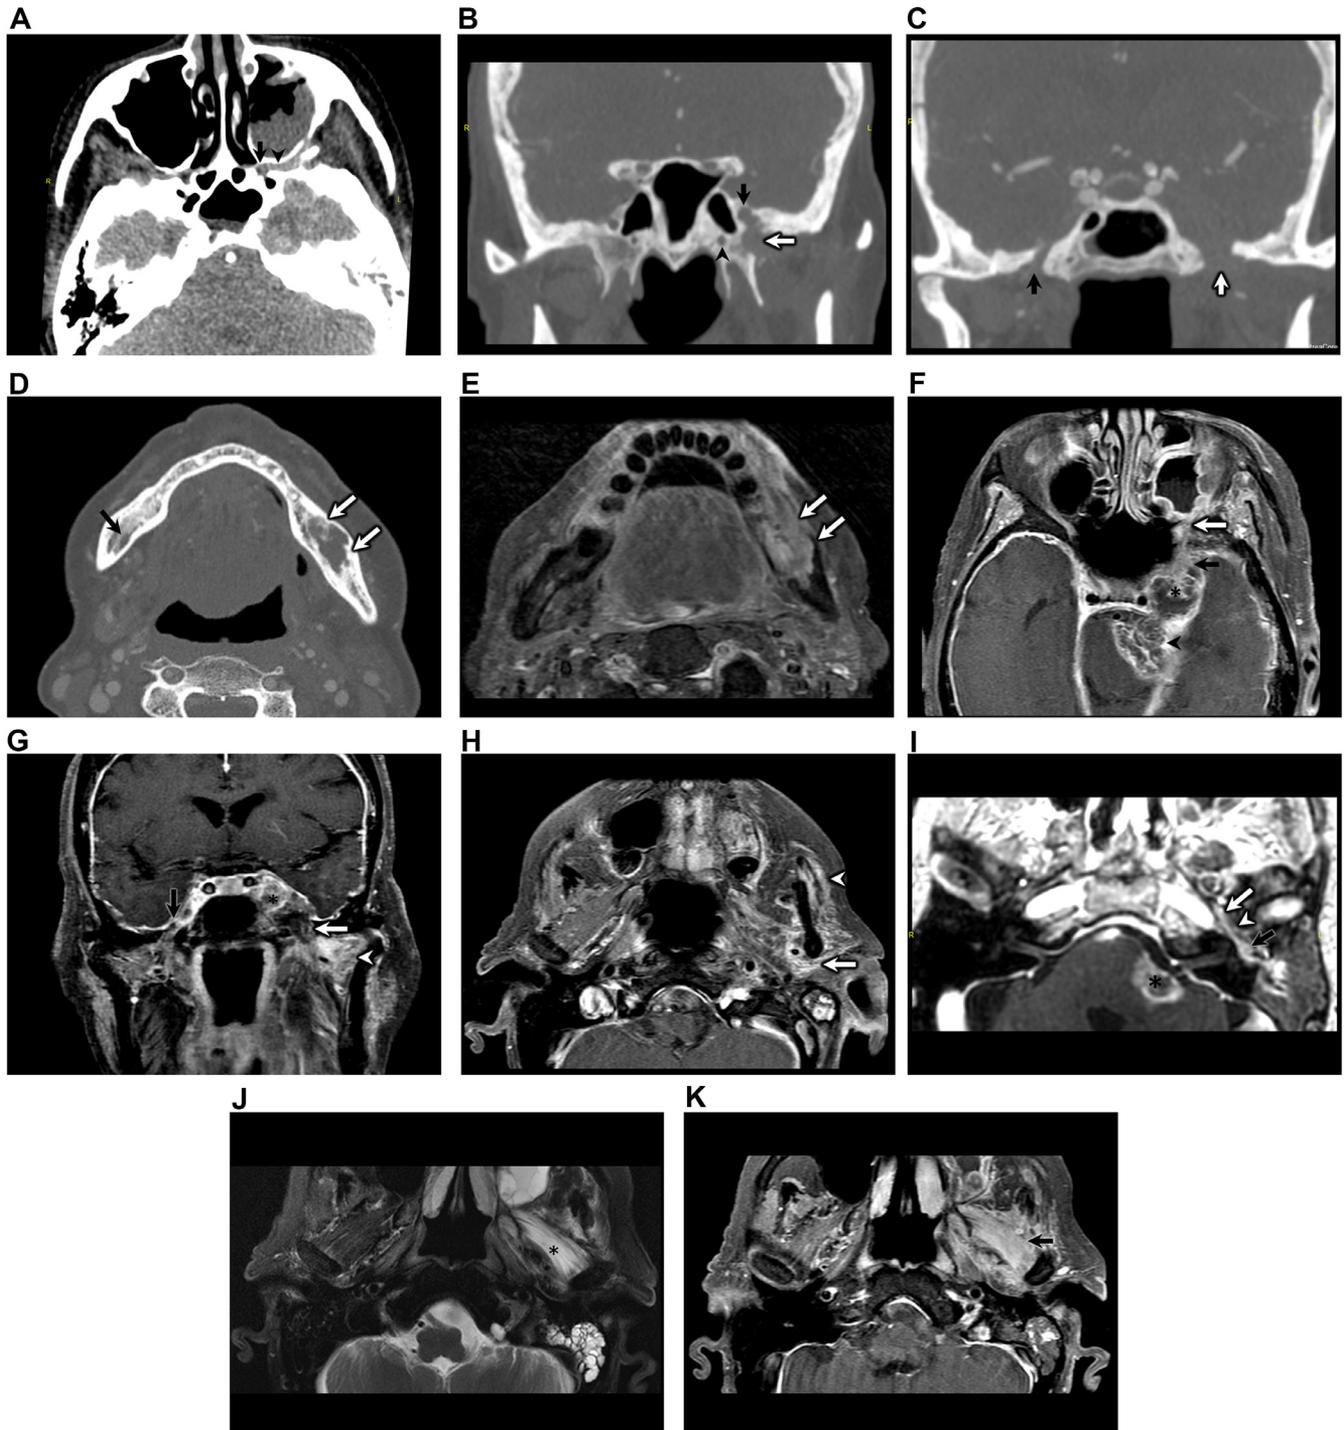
Characteristic imaging features of perineural tumor spread in a 77-year-old female presenting to the emergency room with new onset of left facial paralysis. (A) Axial contrast-enhanced CTA. Abnormal soft tissue density replaces the fat in the left pterygopalatine fossa (black arrow) and extends into the pterygomaxillary fissure (black arrowhead), an ominous sign. Adjacent left maxillary sinus opacification is incidental mucosal thickening. (B) and (C) Coronal reformatted contrast-enhanced CTA in bone window. (B) Classic features of perineural tumor spread are seen including marked enlargement of the left foramen rotundum (black arrow), subtle enlargement of the left vidian canal (black arrowhead) and juxtaforaminal skull base erosion involving the left pterygoid process and greater sphenoid wing (white arrow) adjacent to the left foramen rotundum. Compare this to the normal contralateral right foramen rotundum and right vidian canal. (C) There is marked abnormal widening of the left foramen ovale (white arrow). Compare this to the normal right contralateral foramen ovale (black arrow). (D) Axial contrast-enhanced CTA in bone window. Extensive perineural tumor spread causes both widening and erosive changes seen along the left inferior alveolar nerve canal (white arrows). Compare this to the barely perceptible normal distal right inferior alveolar nerve canal (black arrow). (E) Corresponding axial T1-weighted postcontrast fat-saturated image confirms enhancing perineural tumor filling and eroding the left inferior alveolar nerve canal (white arrows). (F). Axial T1-weighted postcontrast fat-saturated
